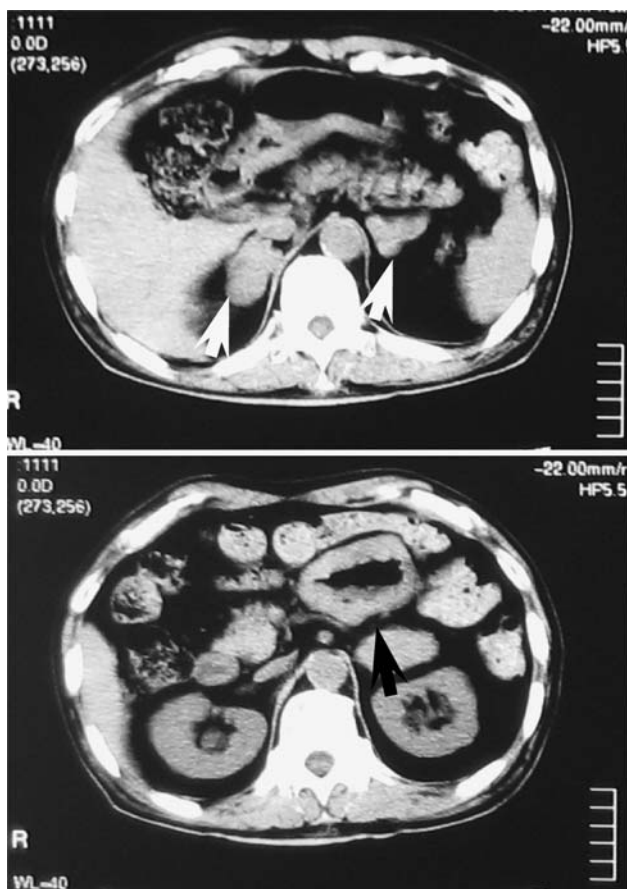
Abdominal computed tomography disclosed large bilateral adrenal masses (\Rightarrow), and there was a thickness of the intestinal wall (\Rightarrow)
